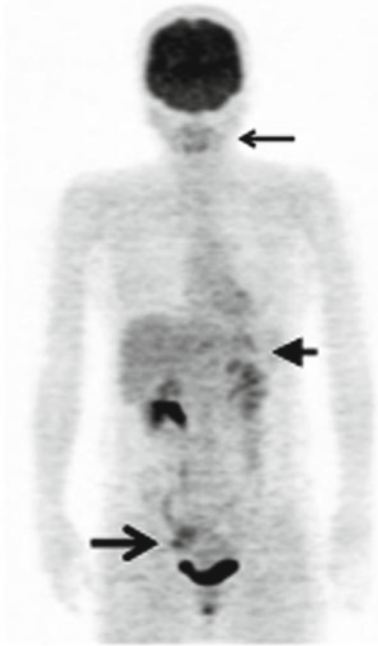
48-y-old, female. Normal distribution of FDG 1 h following intravenous tracer administration. Attenuation-corrected anterior maximum intensity projection (MIP) image. Intense tracer activity in the brain and bladder. In the neck, palatine tonsil lymphoid tissue tracer activity (*small arrow*) is seen. Inferior to the heart is low-level gastric tracer activity (*arrowhead*) and the outlines of the liver, spleen, and kidneys are discernable. In premenopausal women cyclical right ovarian uptake of FDG is seen in pelvis (*large arrow*)
